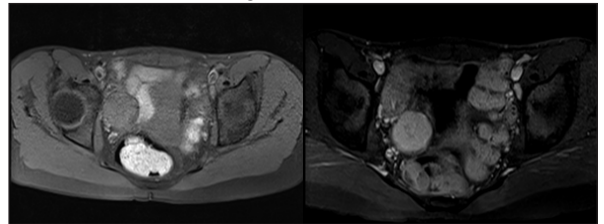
T1FS post contrast MRI sequence showing minimal enhancement similar to myometrium.
